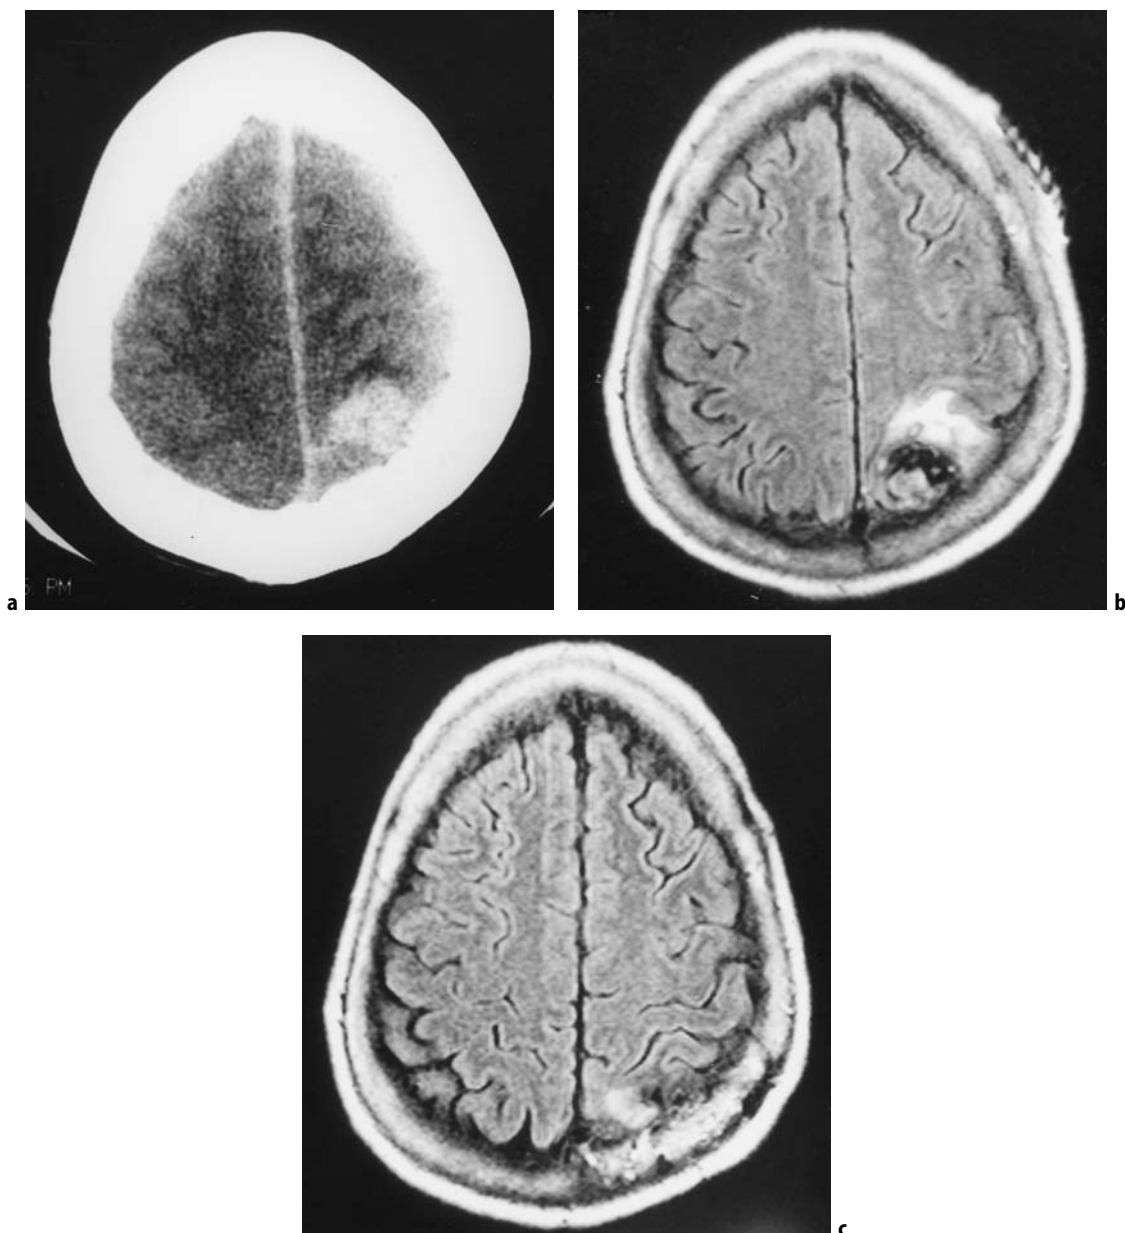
Case 4: A 65-year-old female presented with sudden headache, confusion and trace right-sided weakness. a An urgent axial head CT scan revealed a left-sided parietal hyperdensity. b An axial T1-weighted non-contrast MRI through the area of abnormality revealed a 2-cm cavernous malformation with areas of hemorrhage of various chronicity. An acute intraparenchymal bleed was noted anterior to the lesion. The woman was brought to the operating room and the lesion was removed. c A post-operative axial T1-weighted non-contrast MRI confirmed the successful resection of her cavernous malformation. With a brief period of rehabilitation, the patient returned to her usual state of good health.
